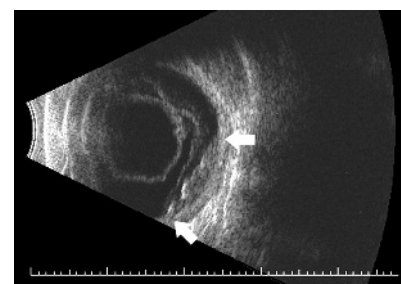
B-scan ultrasound of the right eye demonstrates a subretinal mass of moderate internal reflectivity (white arrows) accompanied by vitreous haemorrhage.
